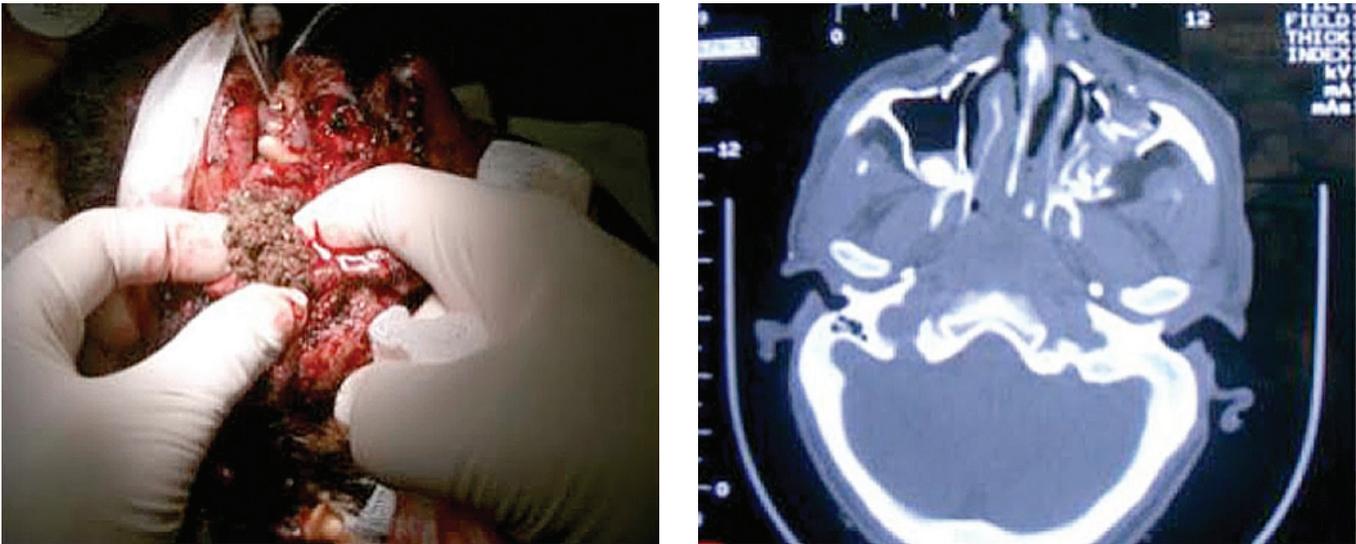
(Left) A piece of shrapnel removed from a combat casualty suffering penetrating fragmentation injuries to the face. (Right) Axial CT image revealing shrapnel that has perforated and comminuted the thin bones of the midface.
